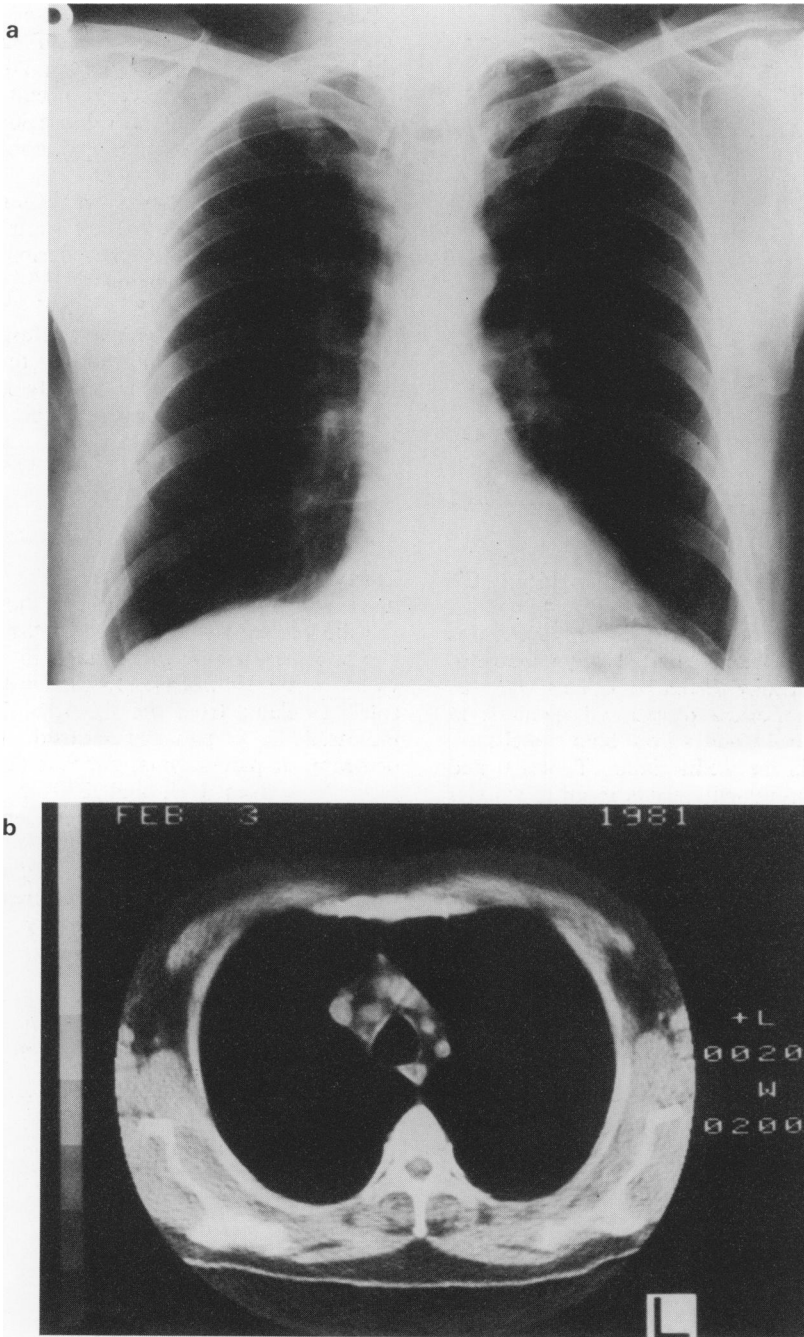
Male age 56 with NHL. (a) CXR: Wide upper mediastinum interpreted as lymphadenopathy. (b) CT scan shows widely spaced normal vessels but no enlarged nodes.
